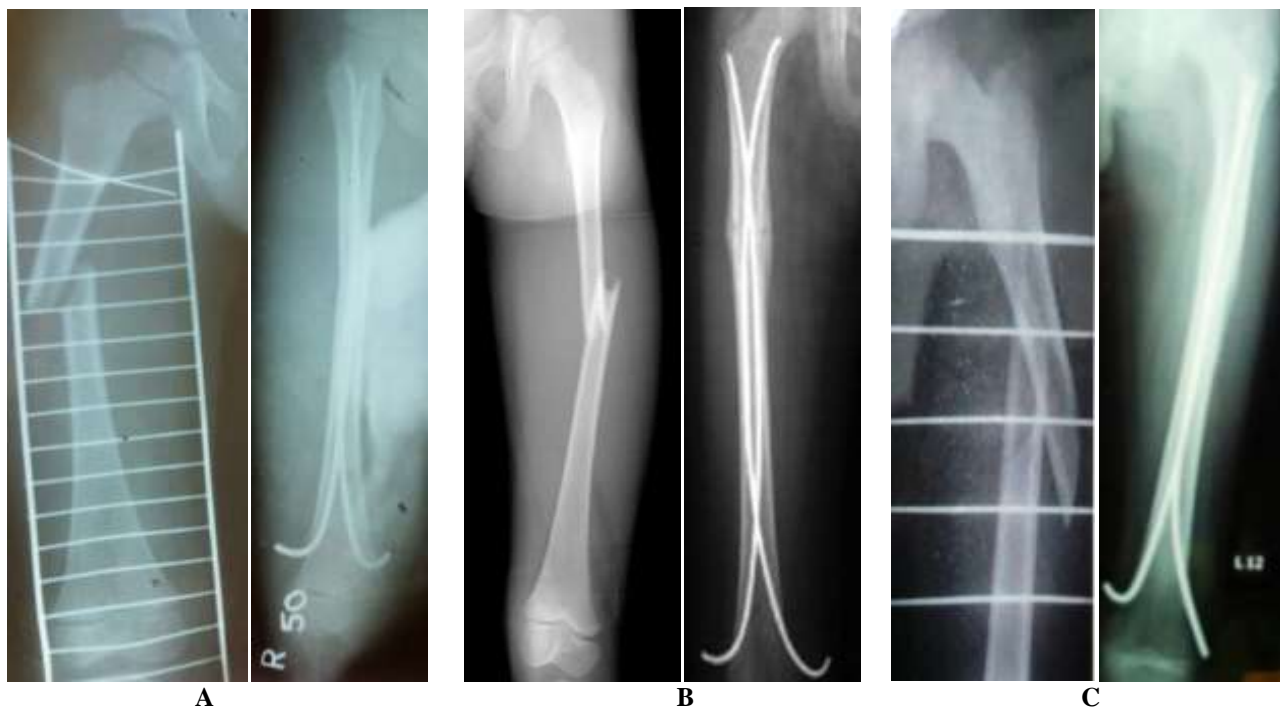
Preoperative and Postoperative X-Rays of Paediatric Femoral Fracture Fixed With Tens
